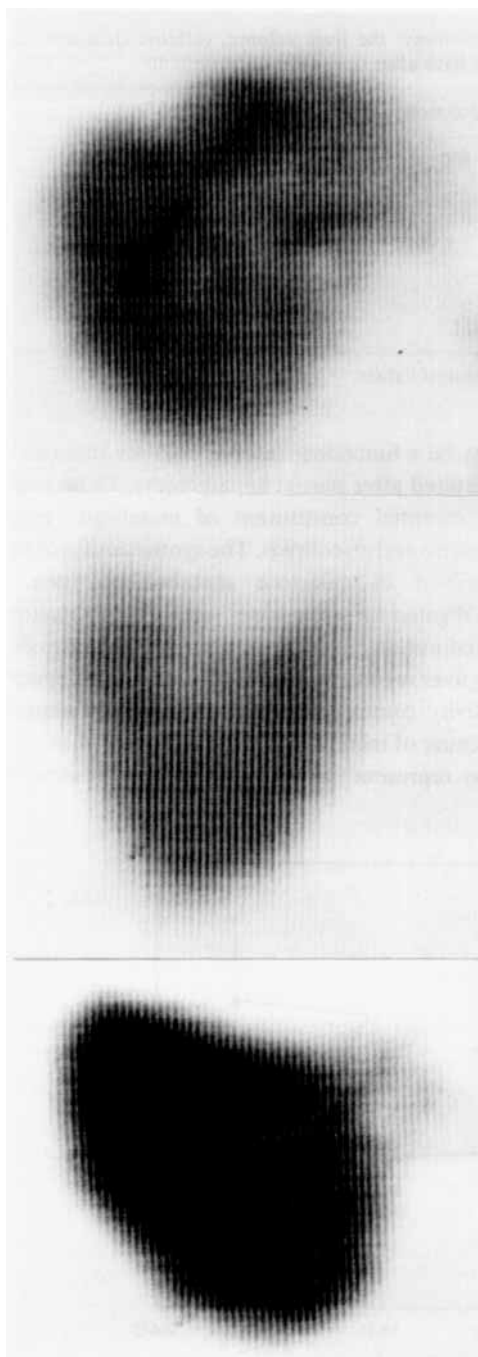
SPECT images of the liver before and after partial left hemihepatectomy. In this patient a left hemihepatectomy was done because of a metastasis in the left liver lobe. Before operation the liver size by SPECT was 2110 ml (upper panel); after operation, 1320 ml (middle panel); and during the regeneration phase 20 weeks after operation, 1670 ml (lower panel).
